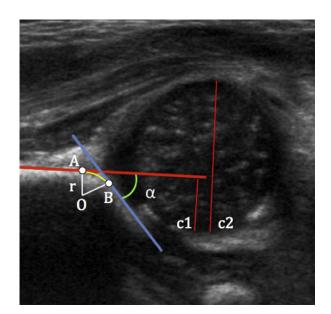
Ultrasound tracings conducted by observers on custom MATLAB software (The MathWorks, Natick, MA, USA). The *red line* represents the iliac wing (baseline), and the *blue line*, the acetabular roof. Acetabular arc length was defined as the distance from A to B, and acetabular radius of curvature as the average distance between O-A and O-B. The ratio of lengths c1/c2 was used to calculate acetabular coverage, and the α angle is noted.
